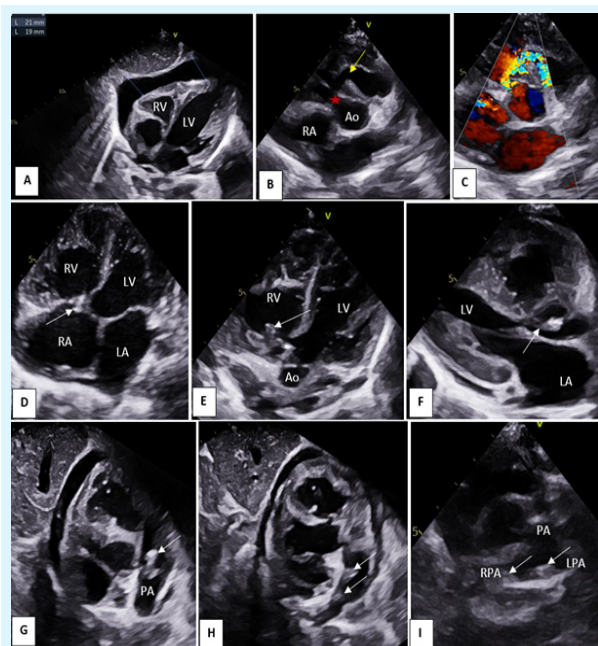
Echocardiographic findings of a perimembranous VSD complicated by infective endocarditis and pericardial effusion;
